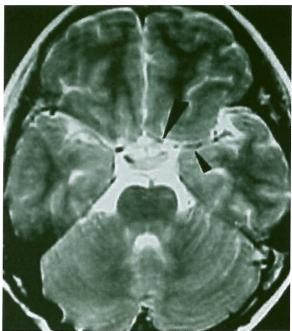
MR brain imaging prior to treatment. Axial T1-weighted (A) and T1-weighted after intravenous gadolinium administration (B) spin echo MR images showed an isointense mass (arrow) in (A) with central hypointense calcification and homogenous enhancement after gadolinium contrast study. Axial T2-weighted spin echo MR image (C) at circle of Willis showed normal signal void of normal patency of A1 segment (large arrowhead) and M1 segment (small arrowhead). Coronal T2-weighted spin echo MR image (D) also demonstrated the normal supraclinoid portion of bilateral ICA (arrowheads), normal signal of the basal ganglia and thalamus.
